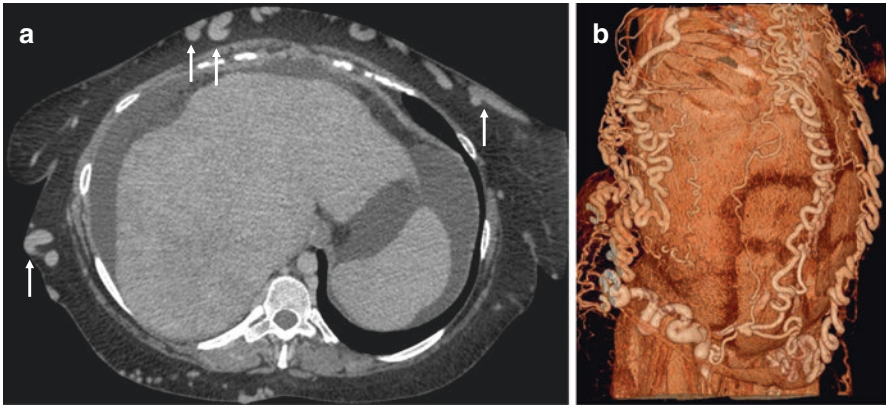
Large parietal collaterals in a 43-year-old female with Budd–Chiari syndrome related to paroxysmal nocturnal hemoglobinuria. Contrast-enhanced CT on the portal venous phase (coronal view) shows large extrahepatic subcutaneous venous collaterals (arrows) in (a). Three-dimensions of volume rendering (b) highlighting subcutaneous derivation pathways. The heterogeneity of hepatic parenchyma and the liver dysmorphism are also well depicted. The large subcutaneous collaterals suggest chronic obstruction of the inferior vena cava
